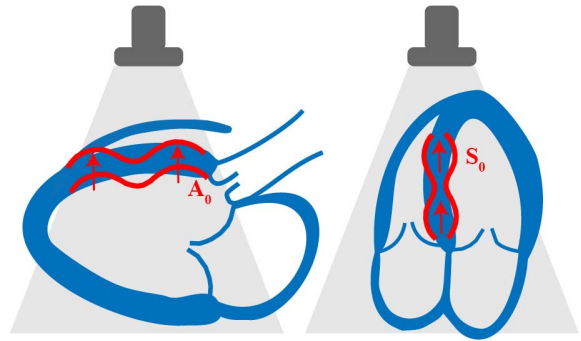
In the parasternal long-axis view, mainly transversal particle motion is measured (left), while in the apical four-chamber view mainly longitudinal particle motion is measured (right) because of the angle dependence of TDI. It could be expected that if an A_0 -mode and an S_0 -mode are induced by the AVC, the A_0 -mode dominated by transversal motion is mainly measured in the parasternal view, while the S_0 -mode is mainly measured in apical view.
